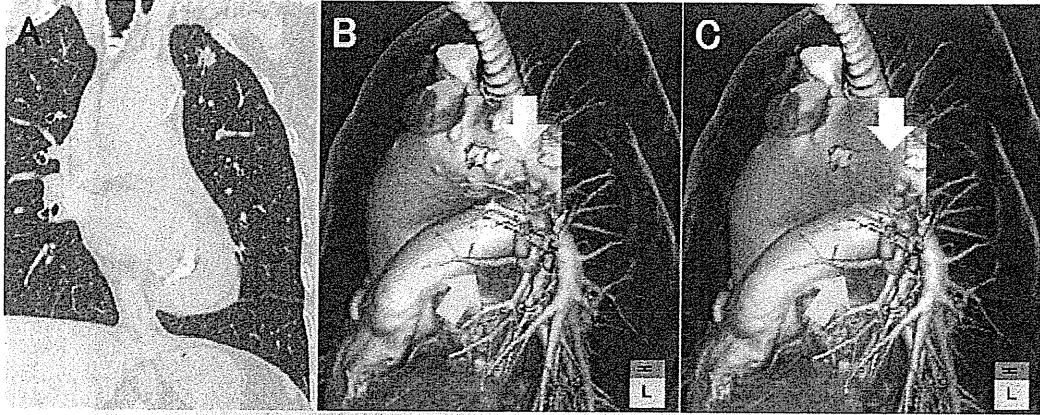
An 82-year-old female. (A) A solid lung cancer in the left S1 + 2 segments is seen on coronal CT; the maximal tumor diameter is 1.2 cm. (B) 3D-CTA of the left upper lobe. The relevant intersegmental veins are V3b, between S3 and S4 (yellow arrow), and V1b, between S1 + 2 and S3 (white arrow). (C) 3D-CTA with the virtual safety margin. Because V3b is running through the margin but V1b is running within it, S1 + 2 + S3 segmentectomy is necessary. (For interpretation of the references to color in this figure legend, the reader is referred to the web version of the article.)
